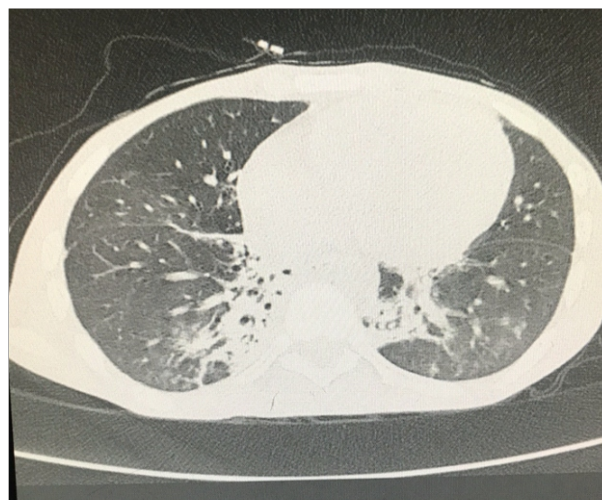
Computed Tomography of thorax suggestion of consolidation in bilateral lungs and cavity and fibrotic bands in the right lung
